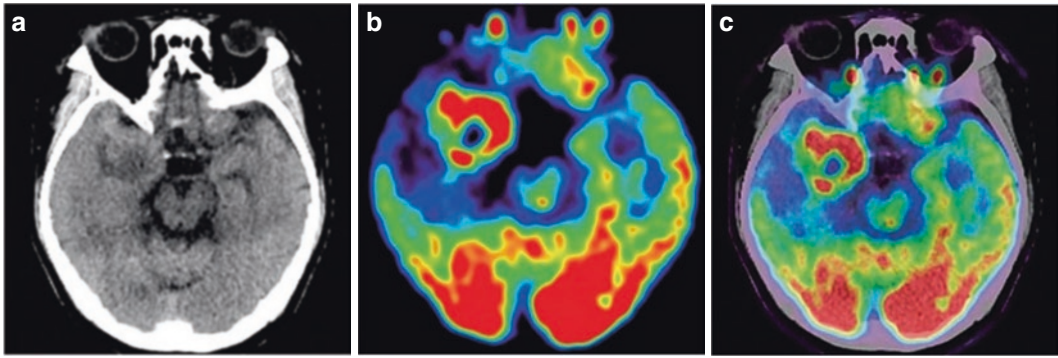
High-grade glioma of the right temporal lobe. A 52-year-old male patient whose transverse brain CT shows a mass in the right temporal lobe, with a hypodense center and slightly hyperdense rim (a). Transverse ^{18}F -FDG PET (b) and integrated ^{18}F -FDG PET/CT (c) show
